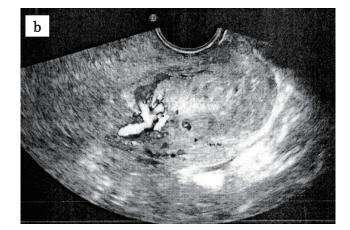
Ultrasonographic images at our hospital. A 4-cm sized mass was detected near the internal uterine os indicated by arrows (a). The mass was diagnosed as a retained product of conception with hypervascularity (b).
